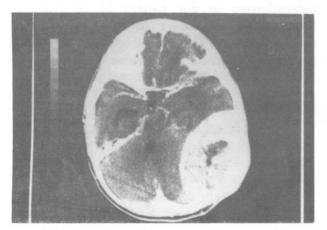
Contrast-enchanced axial computed tomographic scan showing an extracerebral mass in the left parieto-occipital convexity.
